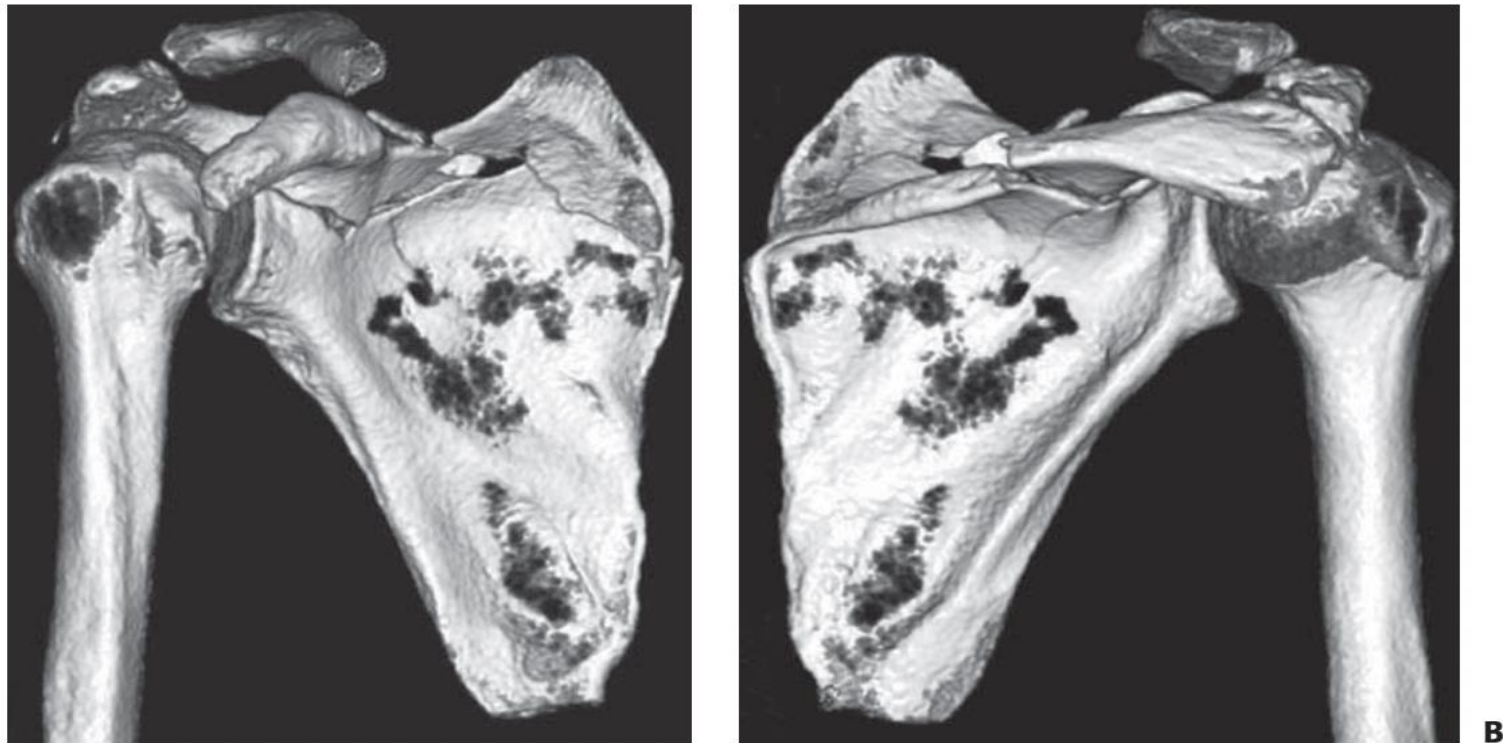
Fractures of the scapular processes (fractures of “upper” scapula) in 3D CT reconstruction. A: Anterior aspect. B: Posterior aspect. Both views demonstrate an intra-articular fracture of the coracoid base, a fracture of the superior angle, a fracture of the scapular spine, and a fracture of acromion. (Courtesy Prof. Zwipp.)
